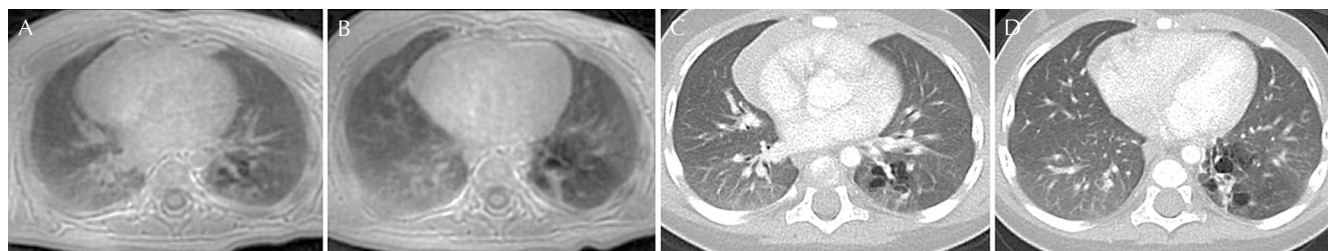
Multiple cystic lesions in the left lower lung in a 6-month-old girl. Compared with CT, pointwise encoding time reduction with radial acquisition (PETRA) (A and B) demonstrates multiple cystic lesions relatively well, except for small cystic lesions (C and D). The area of the cystic lesions is comparable between PETRA and CT.
